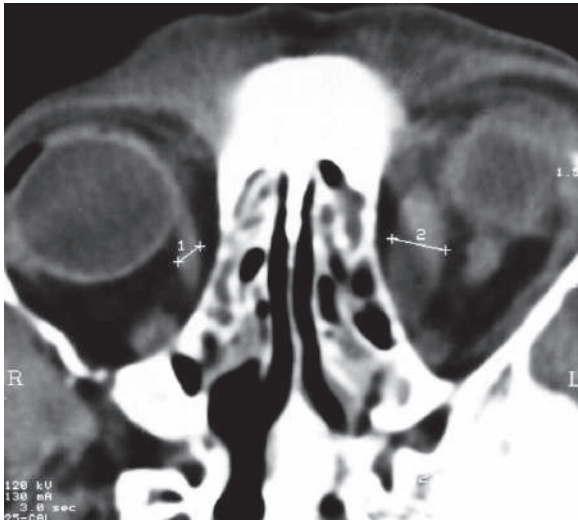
Axial ophthalmic CT image of a patient with Grave's ophthalmopathy shows marked thickening of the medial rectus muscle of the left eye. Notice the difference in the medial rectus belly thickness (2) in comparison with the right eye (1)
